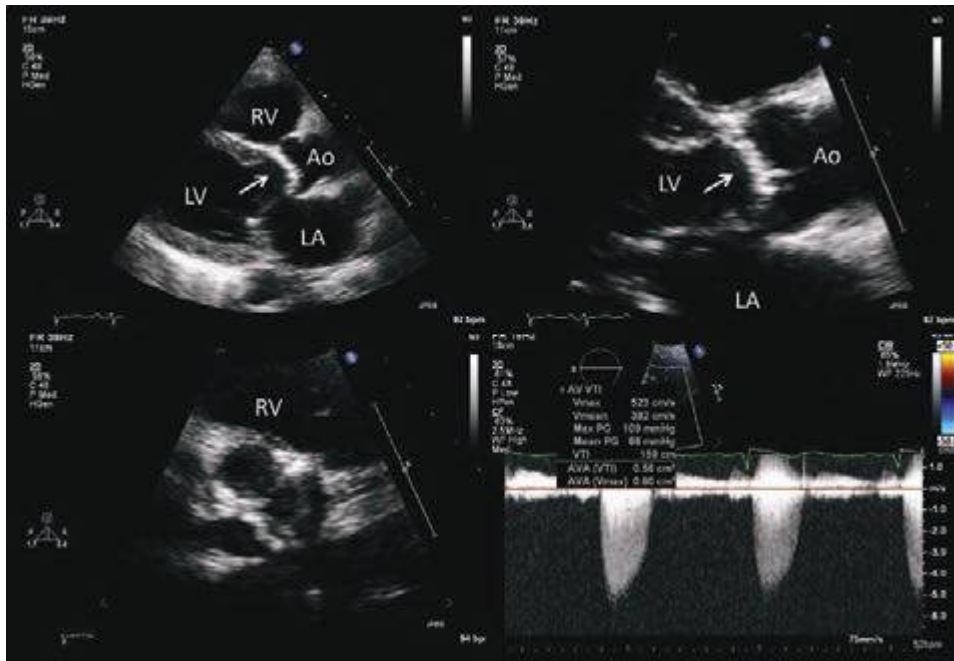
12 A 70-year-old patient with known cardiac murmur and progressive shortness of breath and a recent episode of syncope. Echocardiography shows severe calcific aortic stenosis. A heavily calcified aortic valve (*arrow*) is shown in the parasternal long-axis views (*top panels*) and short-axis view (*bottom left*). Doppler interrogation shows a peak transaortic velocity of 5.2 m/s consistent with a peak instantaneous gradient of 109 mmHg and a mean gradient of 66 mmHg, and a corresponding aortic valve area of $<0.6\text{ cm}^2$ (*lower right*). Ao, aorta; LA, left atrium; LV, left ventricle; RV, right ventricle. (See Videos 271e-8, 271e-9, and 271e-10.)
